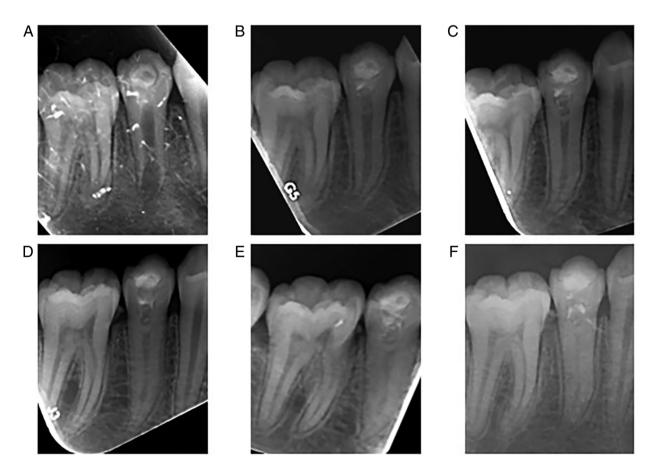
5-year follow-up periapical radiographs of tooth #45. (A) Preoperative radiograph. (B) 1-year, (C) 2-year, (D) 3-year, (E) 4-year and (F) 5-year follow-up radiograph after the regenerative endodontic procedure.
